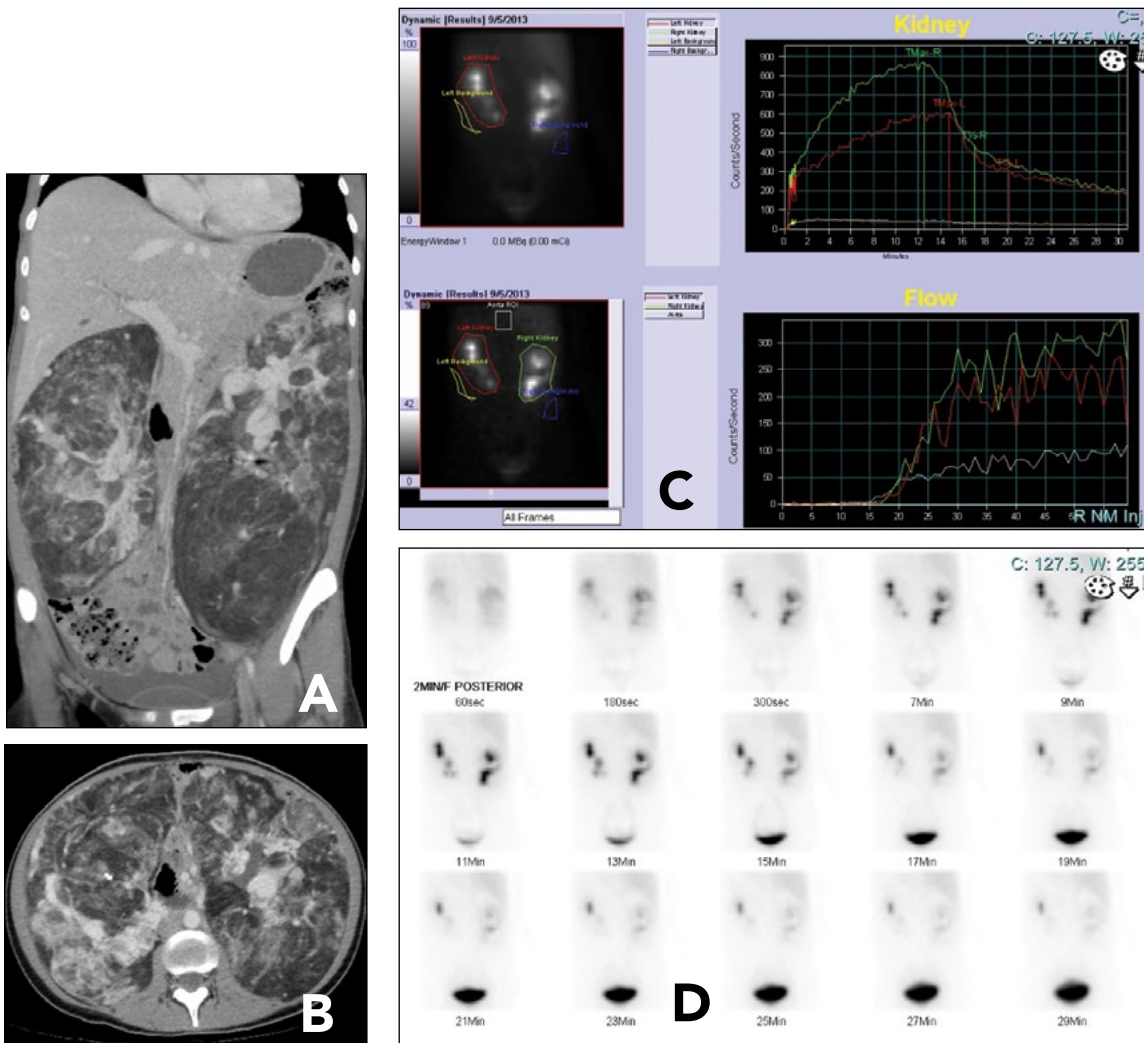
An imaging study in 2013 of a 31-year-old female with bilateral large renal angiomyolipoma. She had selective arterial embolization for active bleeding twice on the right side (2005 and 2008) and once on the left side (2008). A. Coronal CT image shows the right kidney measuring 20.9x10.4 cm and left kidney 22.7x10.6 cm craniocaudally and transversely respectively. B. A transaxial CT image showing right kidney dimensions of 14.8x9.5 cm and left kidney dimensions of 18.3x10.5 cm. C. Technetium MAG3 diuretic renogram showing adequate perfusion and cortical uptake with slow transit and progressive accumulation of tracer in the dilated collecting system (delayed excretion showed good response to furosemide at 10 minutes). D. Static images of the renogram. Serum creatinine at the time of the study was 54 $\mu\text{mol/L}$ and $\text{eGFR} >60 \text{ mL/min/1.77 m}^2$. MAG3=mercaptoacetyl triglycine.
